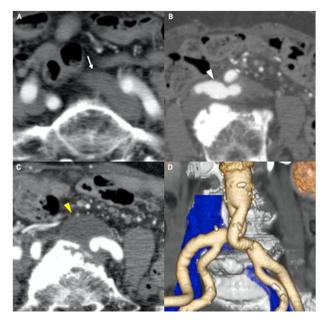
Images of preprocedural examinations. Short-axis image before Y-grafting (A), short-axis images before venous stenting (B, C), and three-dimensional constructed image before venous stenting (D) of multidetector computed tomography. Left iliac common vein (LCIV) (white arrow) was not compressed before Y-grafting (A). Right branch of the bifurcated abdominal vascular prosthesis compressing the LCIV (white arrowhead) (B). Dilated native aneurysm wall filled with liquid covering the vascular prosthesis and also compressing the LCIV (yellow arrowhead) (C). Kinked and overlapping branches of the vascular graft. LCIV obstructed between the right branch of the vascular prosthesis and the spine (D).
